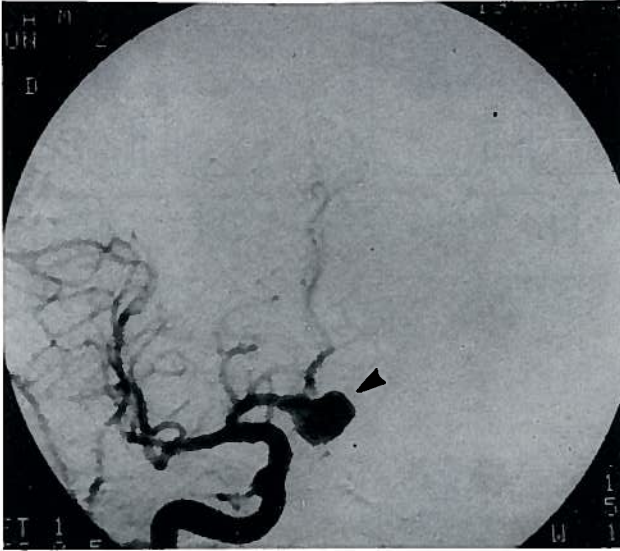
Large incidental anterior communicating aneurysm (arrow) found initially in a CT scan. On surgery the sac was heavily calcified and the lesion was wrapped.
